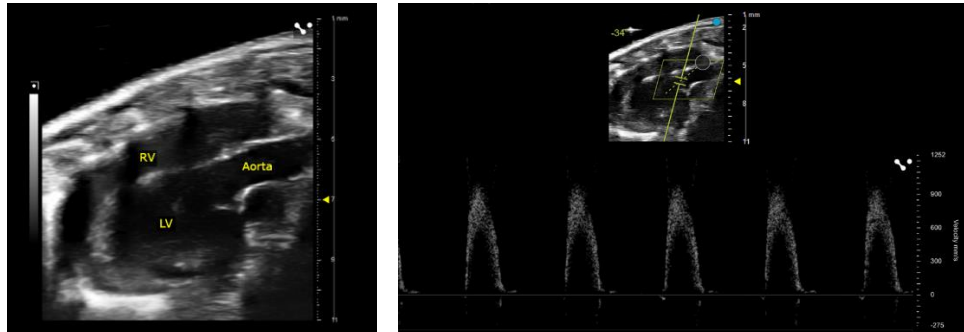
B-mode of ascending aorta (left) and PW Doppler waveform of aortic valve outflow (right) via the suprasternal view.
